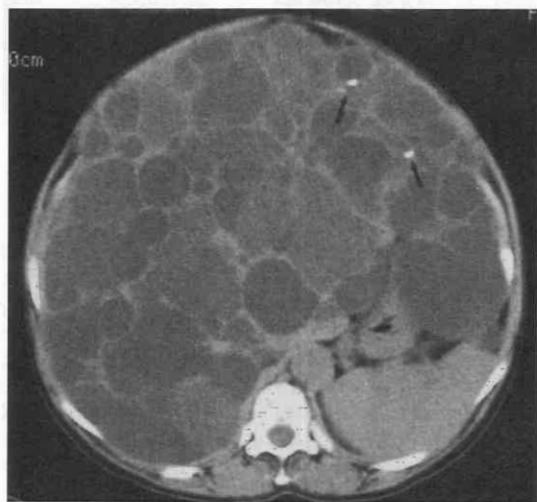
Polycystic kidney and liver disease in a 60-year-old woman. Noncontrast CT scan demonstrates multiple cysts of varying attenuation involving the liver. A few calcifications (arrows) of the cyst walls are present.
